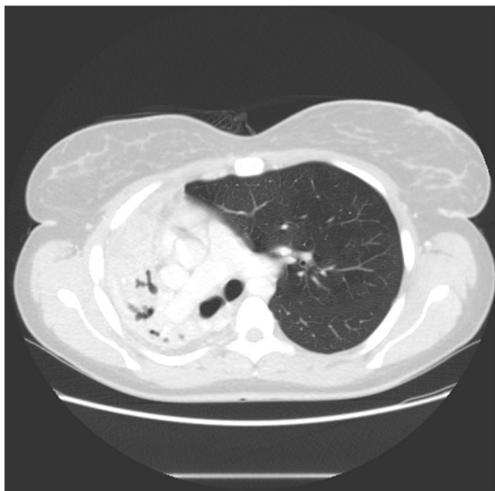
CT scan of the chest showing abcedation with complete obliteration of the right lung
